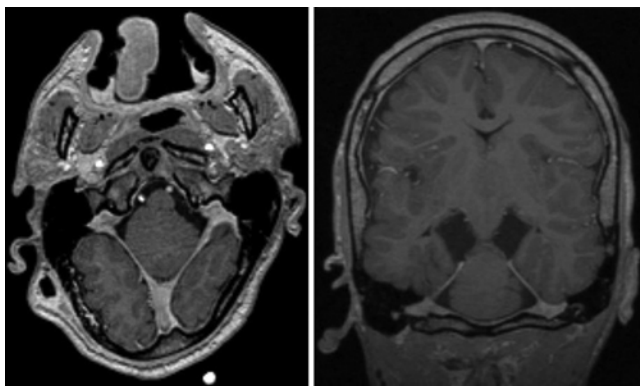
Case 2. Left: Axial T1-weighted MP-RAGE (magnetization-prepared rapid acquisition gradient echo) image demonstrating fused, hypoplastic cerebellar hemispheres consistent with rhombencephalosynapsis. Right: Coronal T1-weighted MP-RAGE image including both fusion of the hypoplastic cerebellar hemispheres and fusion of the thalami.
